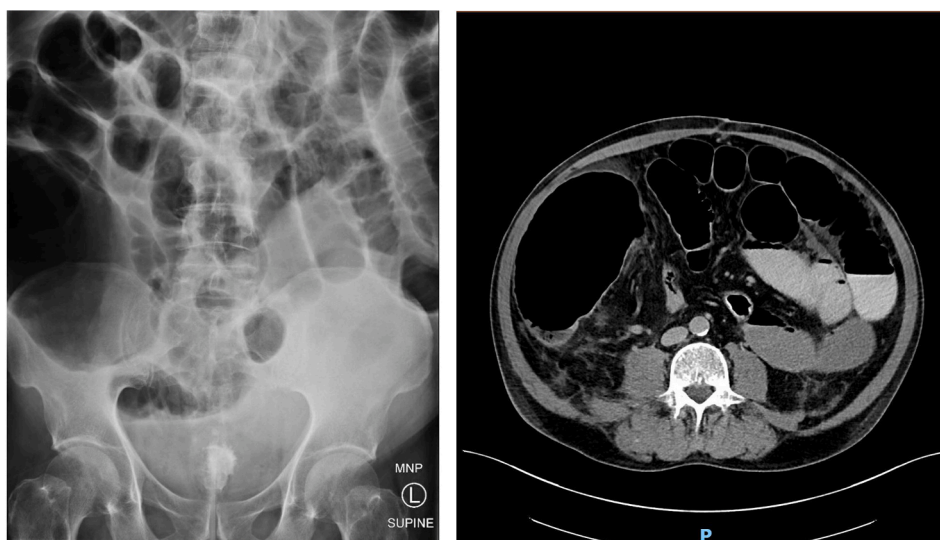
Abdominal X-Ray/CT on admission highlighting gross distension of the caecum.
